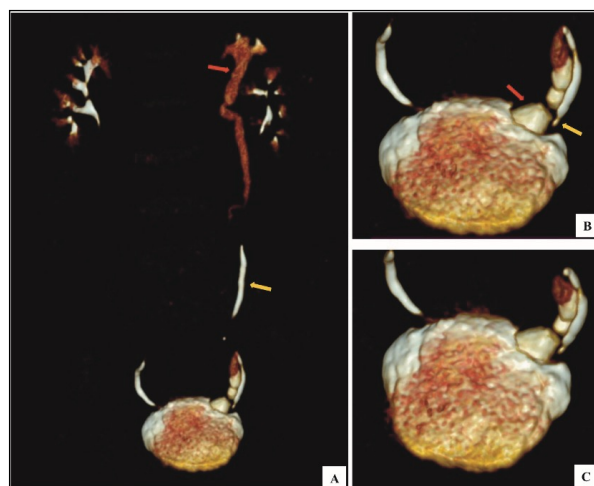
(A-C): Post processed 3D volume rendered CT images. 3D VRT images derived from CT urography shows complete duplication of the collecting system on the left. The upper pole moiety (red arrows) shows calculi in the distal ureter and vesicoureteric junction with upstream hydronephrosis. Inferior moiety (yellow arrows) appears unremarkable. The orthotopic inferior moiety (yellow arrow) is seen draining inferior and anterior to opening of the ectopic moiety.
